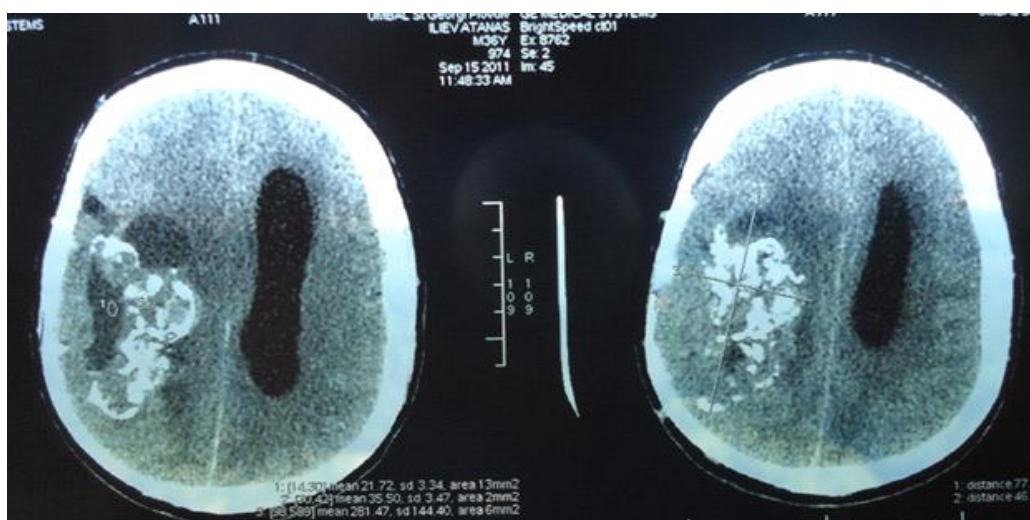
CT image convexity meningioma with calcification
